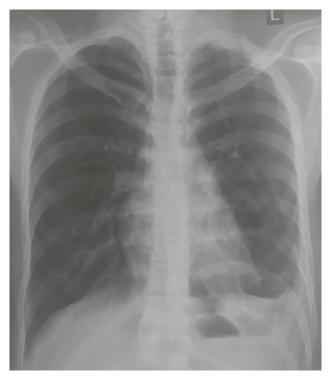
Radiography of the lung and heart at the time of discharge.
